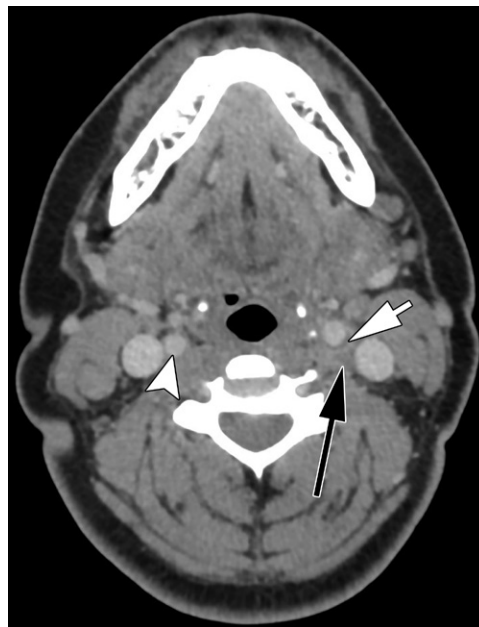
Carotidynia in a 29-year-old woman. Axial contrast-enhanced CT image shows pericarotid infiltration (black arrow). A soft plaque (white arrow) causing mild luminal narrowing also is present at the carotid bulb, with possible enhancement of the adjacent vessel wall. In comparison, the right internal carotid artery (arrowhead) is normal.
